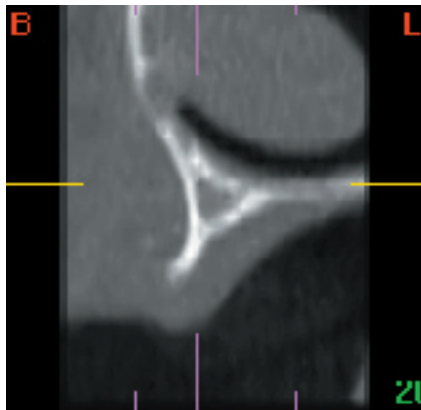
CT cross-sectional image in upper anterior area of a completely edentulous patient showing the knife-edge configuration (B: buccal, L: lingual).
